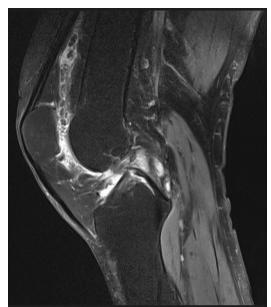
MRI of the knee. Sagittal sequence DPT2 FAT SAT: suppression of the spontaneous T1 hypersignal testifying to the fatty nature of the synovial bangs
